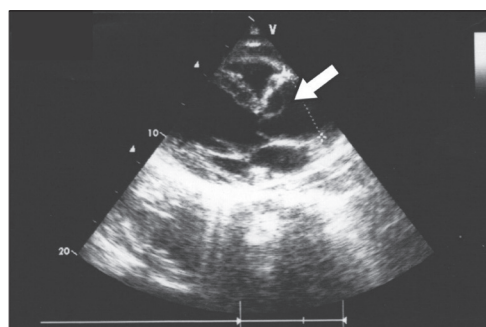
Transthoracic echocardiography (parasternal long axis view): image demonstrating dilated ascending aorta, the intimal flap (arrow) originating in the area of the right aortic cusp, prolapsing into the left ventricle outflow tract
